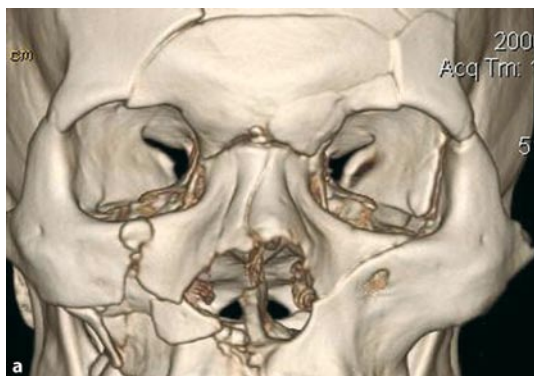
CT imaging of multiple cranial fractures (Lefort III). A young male was involved in an MVC. Several fractures are visible, involving, among others, the orbital rim. a Coronal image; b three-dimensional reconstruction (Courtesy of A. Palkó, Szeged, Hungary)
